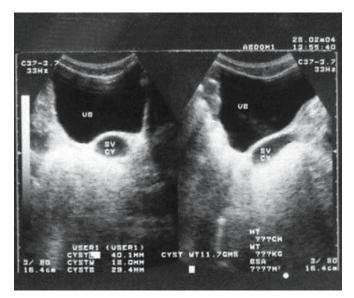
Ultrasound scan shows the left seminal vesical cyst
